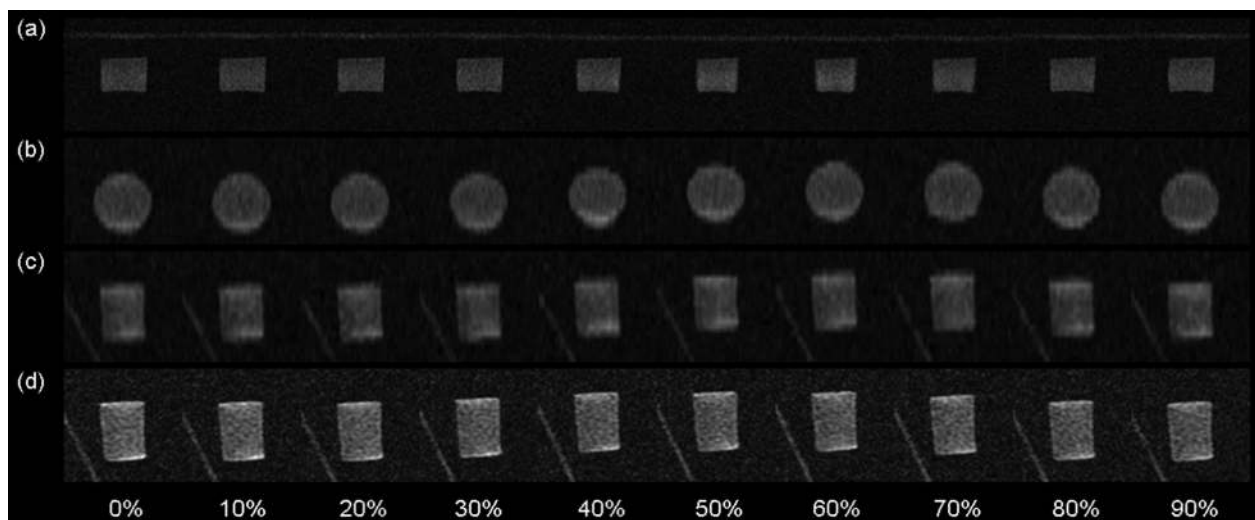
Axial (a), coronal (b), and sagittal (c) 4D-MRI images, and sagittal cine-MRI images (d) of the imaging object.
